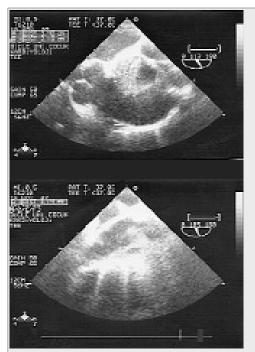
Calcified aortic aneurysm and the thick clot in transesophageal echocardiogram.
